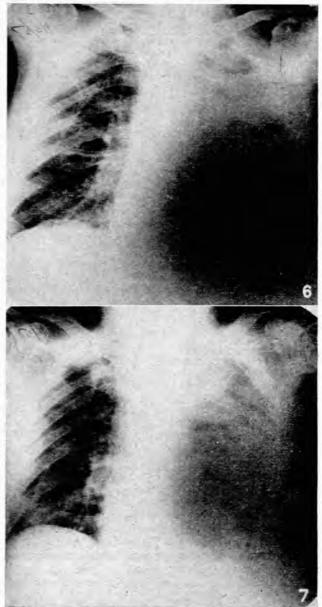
Radiograph of the chest 24 hours after injection of 100 mc. of colloidal radiogold.
